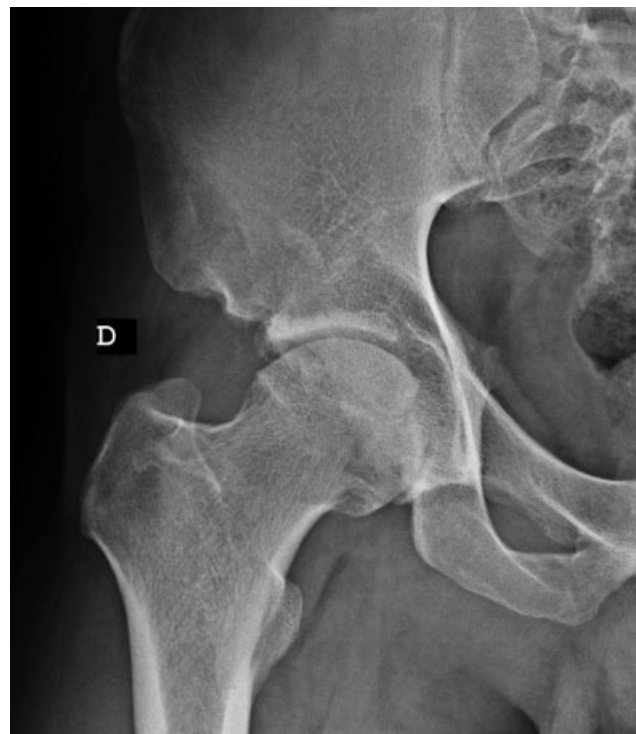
Two-year postoperative radiograph in anteroposterior view of the hip joint, showing the correction of the subspine impingement and of the deformity of the neck-head transition.
